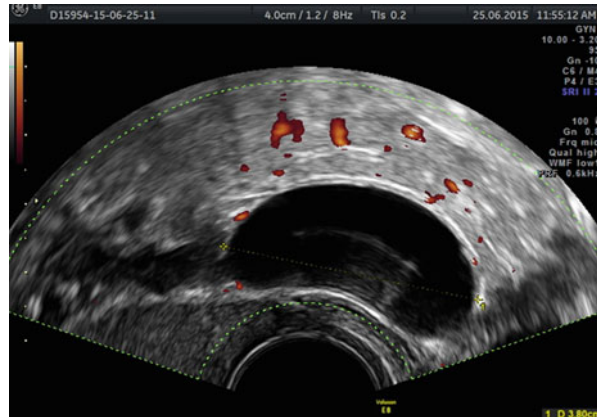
Few vascular spots (color score 2) at color Doppler in case of chronic tubal inflammatory disease
